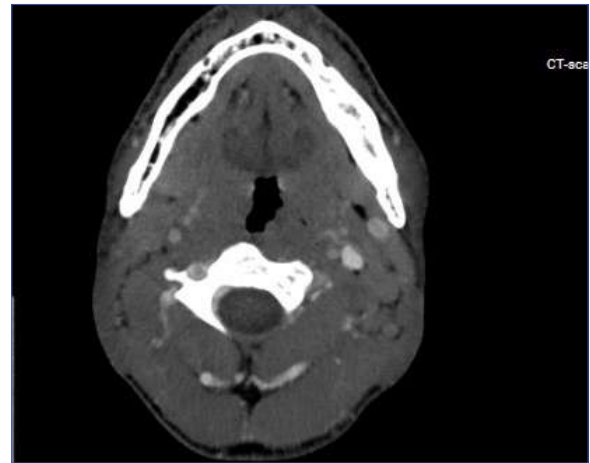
Axial section of a CT scan of the head and neck showing an irregular posterior wall of the oropharynx.
